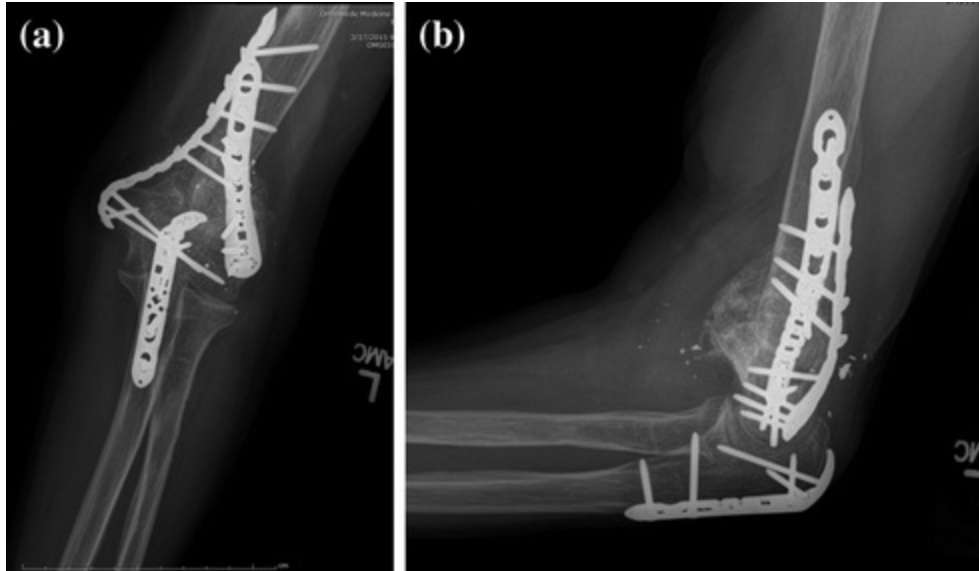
Anteroposterior (a) and lateral (b) radiographs of the nonunion site, which has been reduced and stabilized with a medial and lateral plate and bone grafted with an iliac crest bone graft assisted by an olecranon osteotomy
